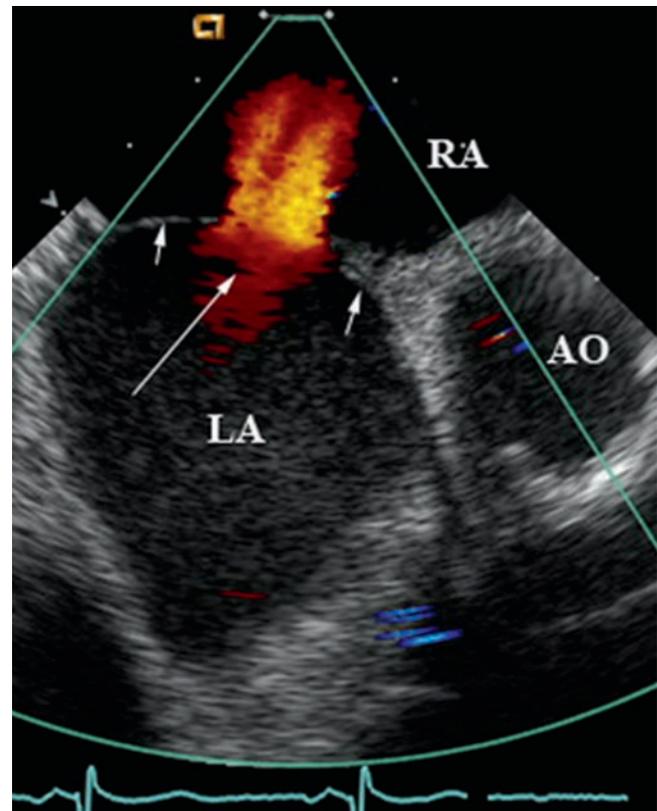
Intra-cardiac echocardiography. Short-axis view at the level of the aortic valve (AO) obtained during intra-cardiac imaging of a secundum atrial septal defect. Colour flow (*long arrow*) depicting flow from the left atrium (LA) to the right atrium (RA) is seen. The rims bordering the defect (*short arrows*) are clearly seen
